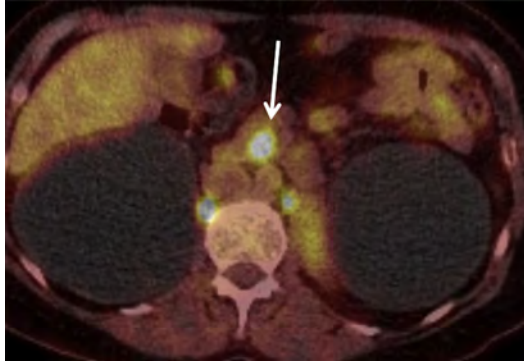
Axial fused PET-CT image in a patient with newly diagnosed PDA shows FDG-avid uncinate process mass (arrow). PET-CT was ordered in this case because the patient had a history of lymphoma, breast cancer, and primary lung cancer.
